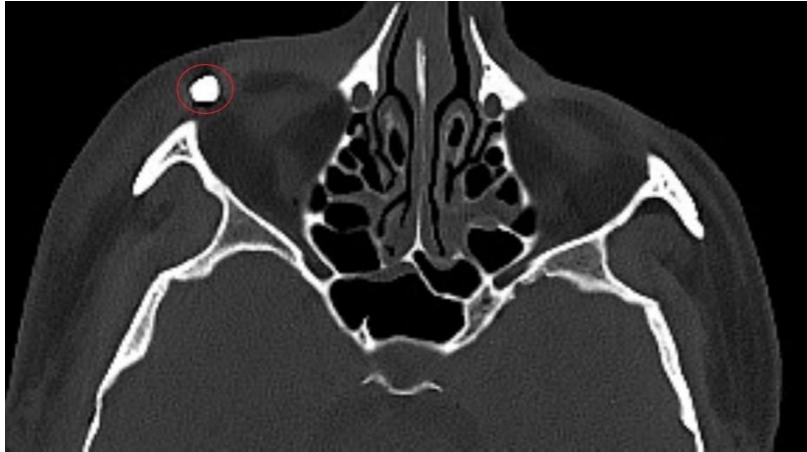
Non- contrast axial CT image showing a well-defined hyperdense foreign body
